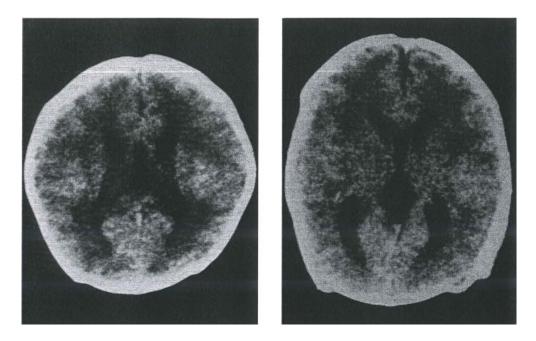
displays two images from CT scans taken when the patients were 4 days old (left, Case 1) and 10 days old (right, Case 2). These scans show that there is mild enlargement of the brain ventricles, but there are no signs of fluid collecting outside the brain.
